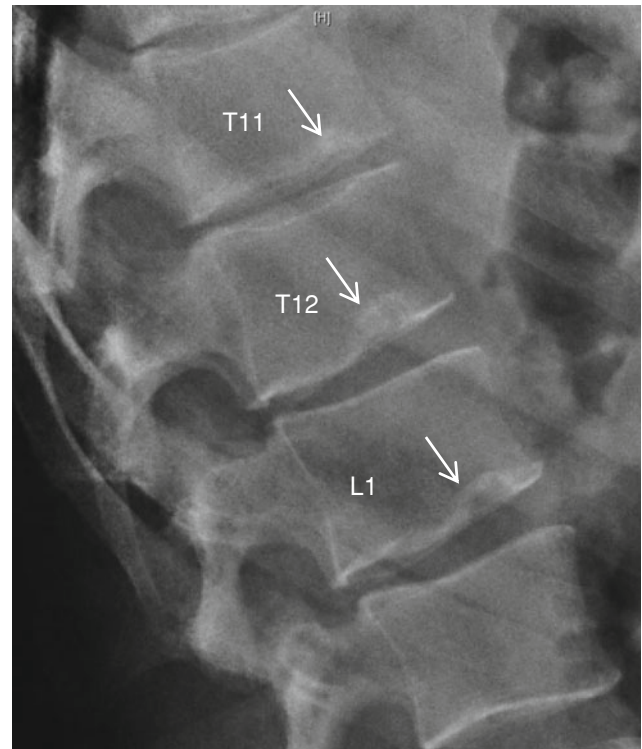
Lateral X-ray of the lumbar spine showing Schmorl nodes of the inferior endplates of T11, T12, and L1. Notice their characteristic rounded contour with sclerotic margin (*arrows*)
